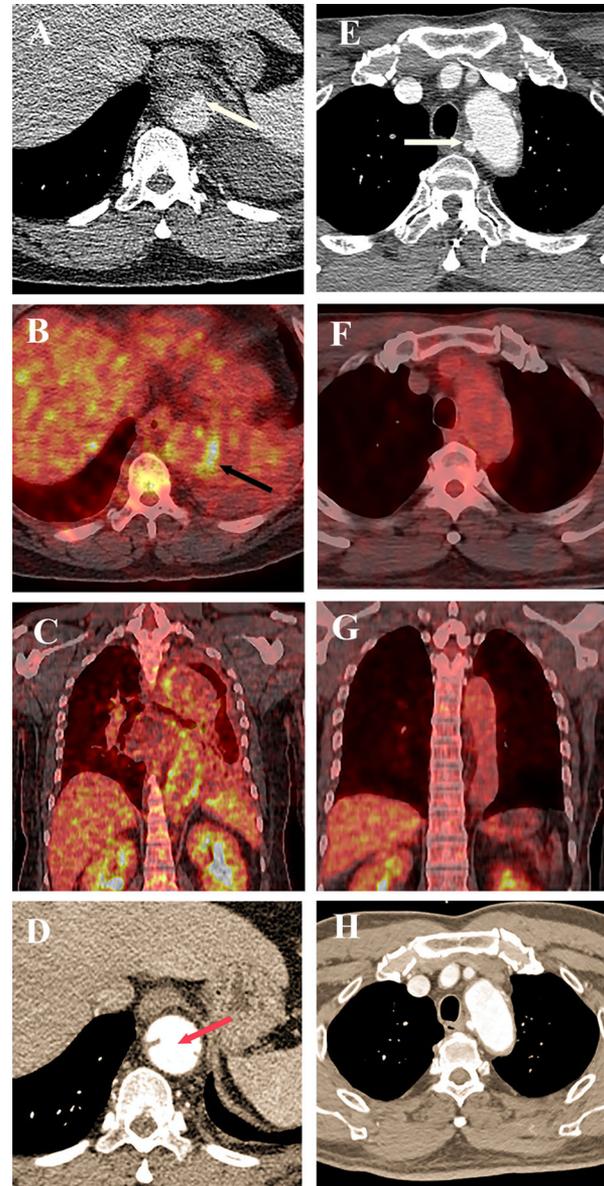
Two representative cases of type B IMH patients with ULP. (ULP, ulcer-like projection; TBR, target to blood ratio). *Left panel*, a 55-year-old man with greater uptake of ¹⁸F-FDG in the aortic wall: A, ULP (arrow) was detected at the middle descending aorta in initial CTA; B–C, accumulation of ¹⁸F-FDG in the aortic wall in PET/CT (arrow), the SUVmax and TBR were 4.8 and 1.3, respectively; D, ULP progressed to classic aortic dissection (arrow) 1 mo after onset. *Right panel*, a 52-year-old man with low uptake of ¹⁸F-FDG in the aortic wall: E, ULP (arrow) was detected at the proximal descending aorta in initial CTA; F–G, no obvious accumulation of ¹⁸F-FDG in the aortic wall on PET/CT, the SUVmax and TBR were 2.7 and 1.1, respectively; H, ULP had no change 35 days after onset.
